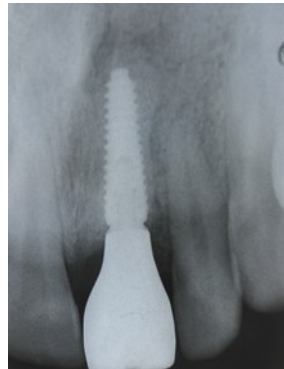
Post-operative x-ray showing correct placement of the implant and fit of the provisional restoration.
